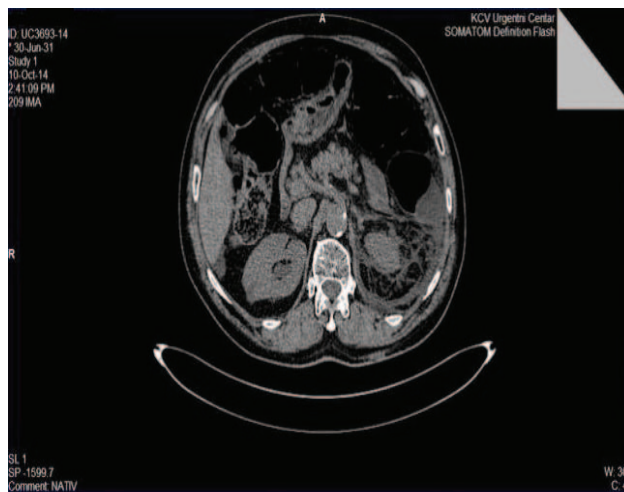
Computed tomography (CT) scan finding of retroperitoneal urinoma predominantly of the left side.
